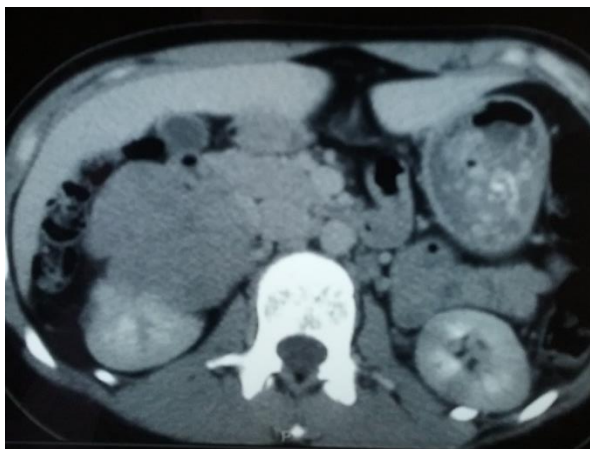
CT Showing Right Adrenal Mass
